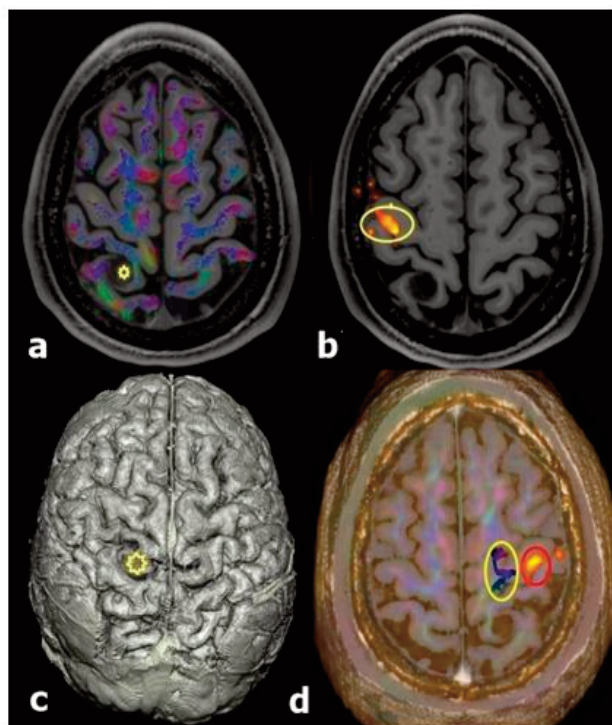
a:Tractography MRI sequence for a patient with refractory epilepsy, showing a tumor (DNET= yellow star), close to the motor cortex.
